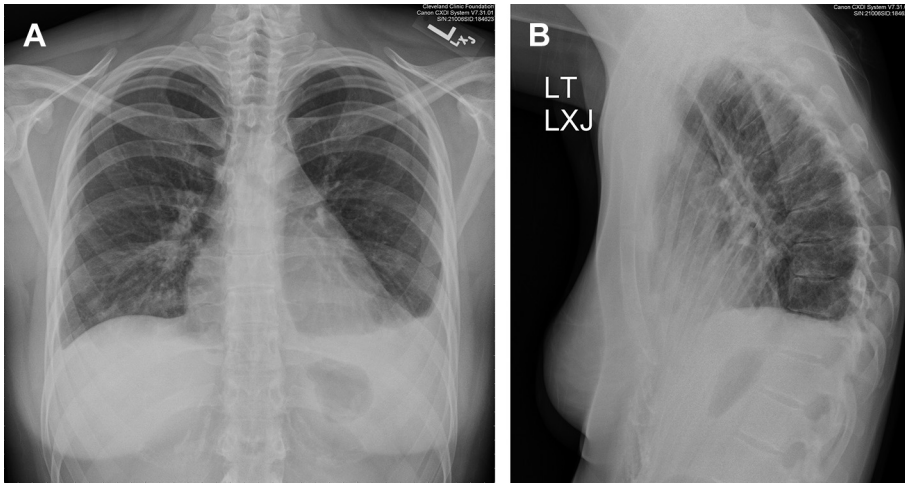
Chest radiograph, posteroanterior (A) and lateral (B) views, revealing a small left pleural effusion.
